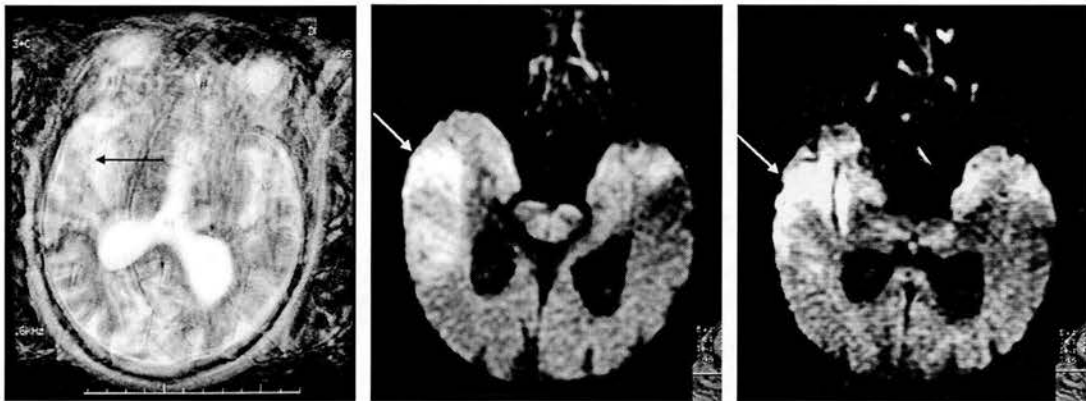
The DWI scan confirmed that a subtle abnormality seen on T2 was an acute infarct
